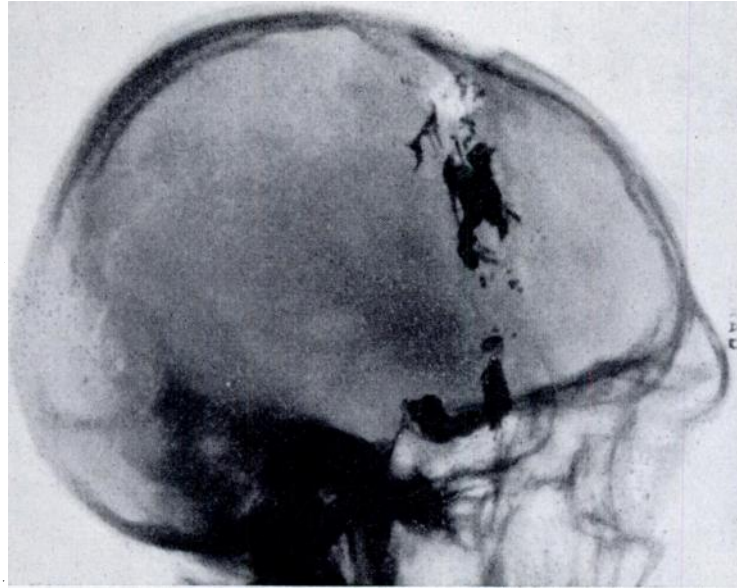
The same case, x-ray lateral picture of the head (excludes post-operative intracranial haemorrhage).
